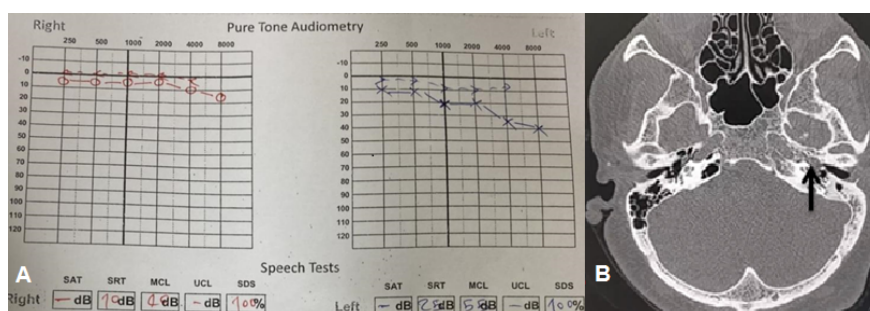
A. Audiogram revealing left-sided conductive hearing loss, with mild sensory-neural loss at high frequency. B- Axial HRCT of temporal bones revealed opacification of the left
